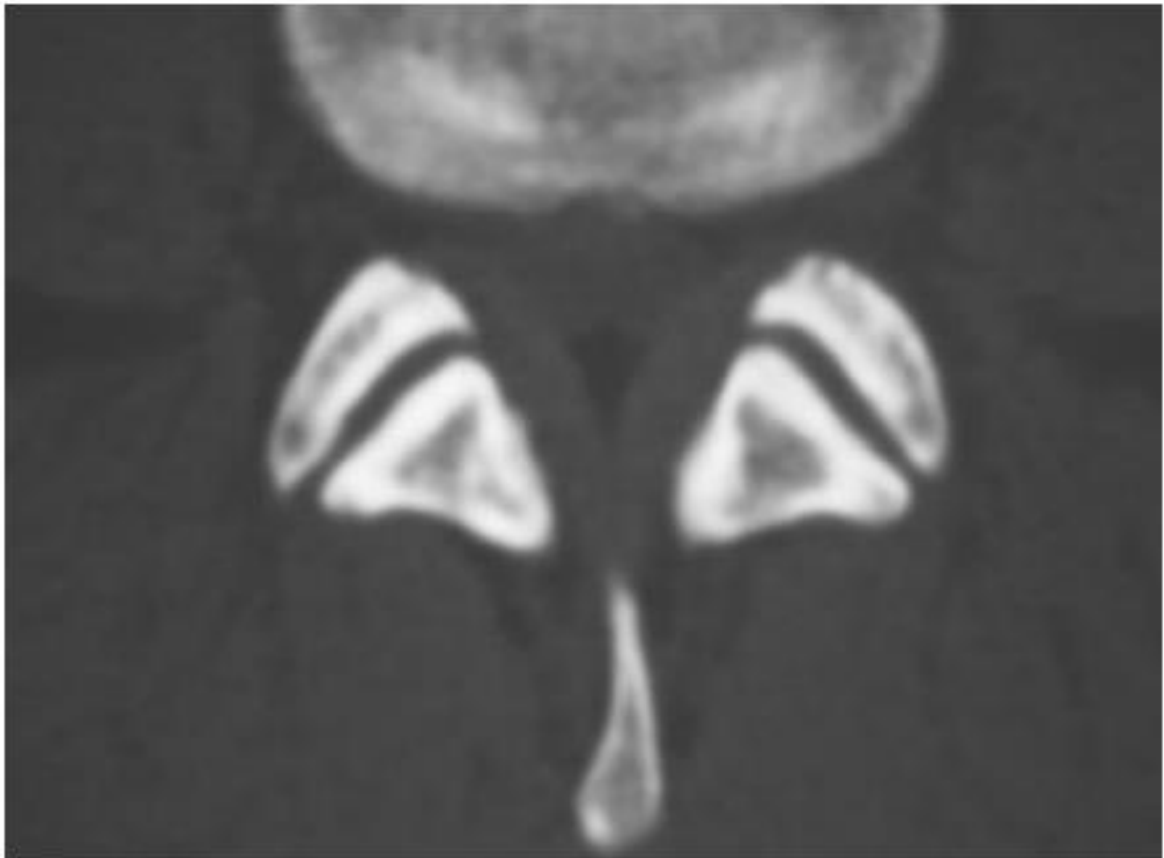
Axial CT image of LFJ.<sup>83</sup>
